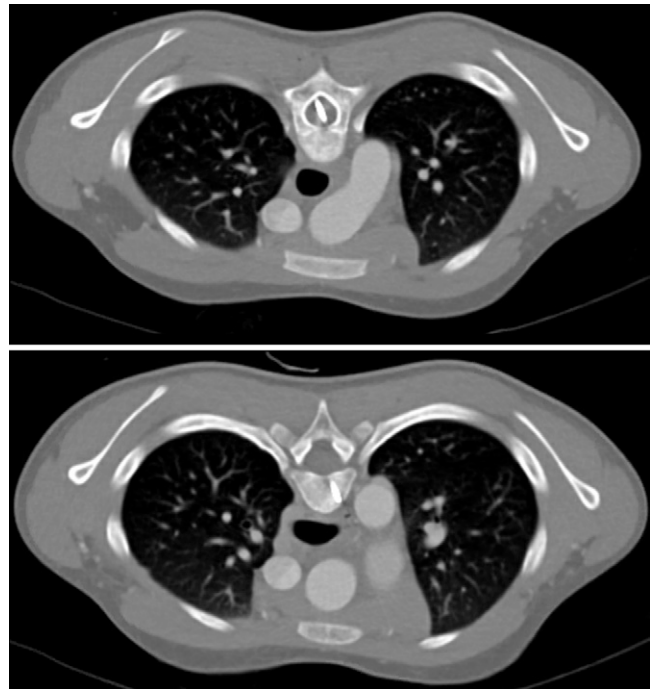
Axial CT scans showing the foreign body bisecting the spinal cord and embedding into the left side of the vertebral body.
